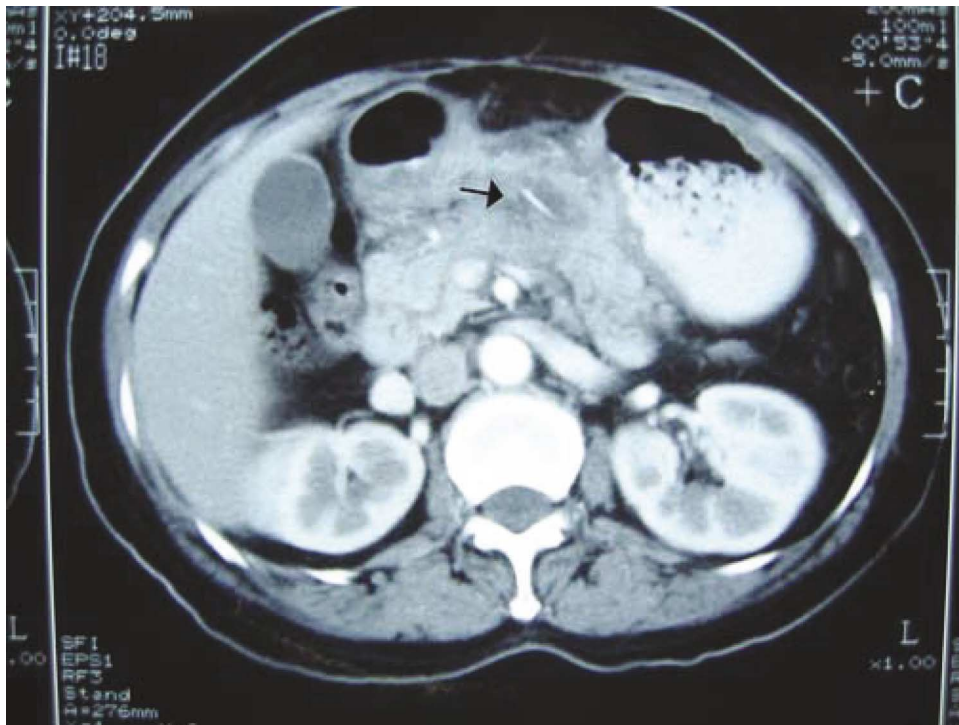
CT scan demonstrating the fish bone within the pancreatic abscess.
